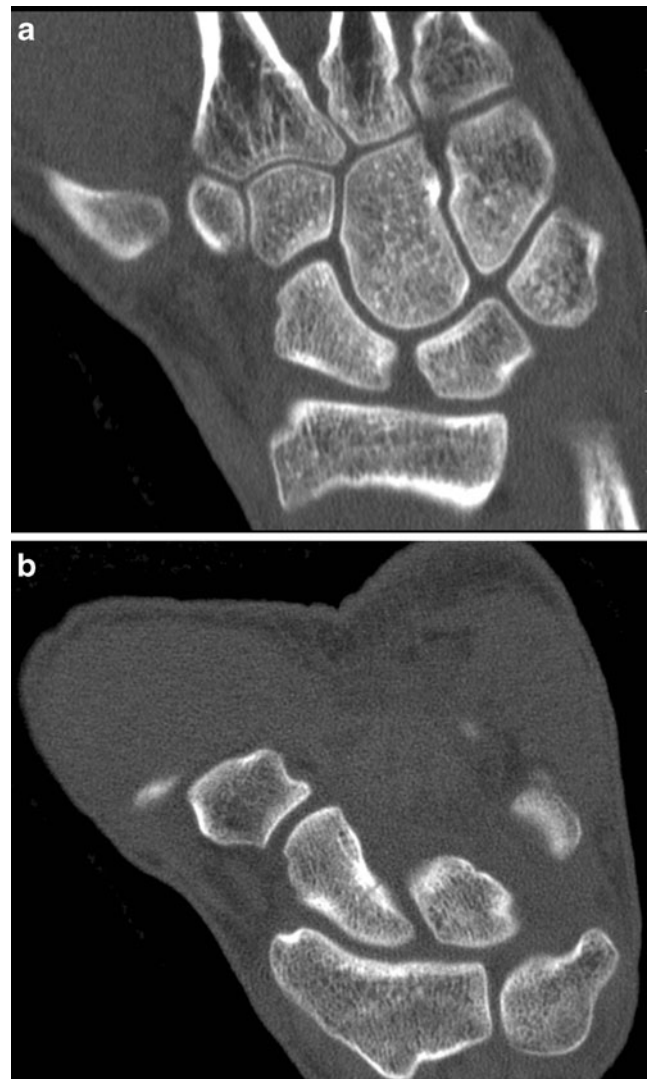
a No fracture line visible on CT scan reformatted in the plane of the wrist (CT-wrist). b The same patient did show a fracture on CT scan reformatted along the long axis of the scaphoid (CT-scaphoid)
